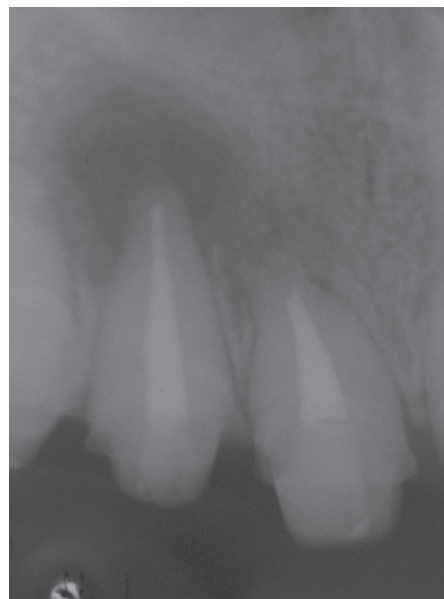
Radiograph of the upper anterior teeth after retrograde filling.
